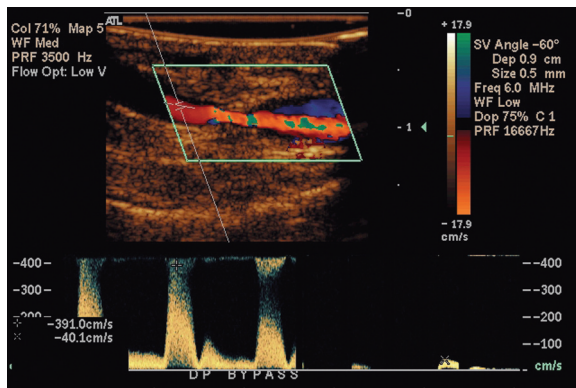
Doppler spectral analysis obtained at the distal femoral to dorsalis pedis artery vein bypass graft demonstrated critical stenosis by PSV step-up ratio of 9.8 (391 cm/s over 40 cm/s)
